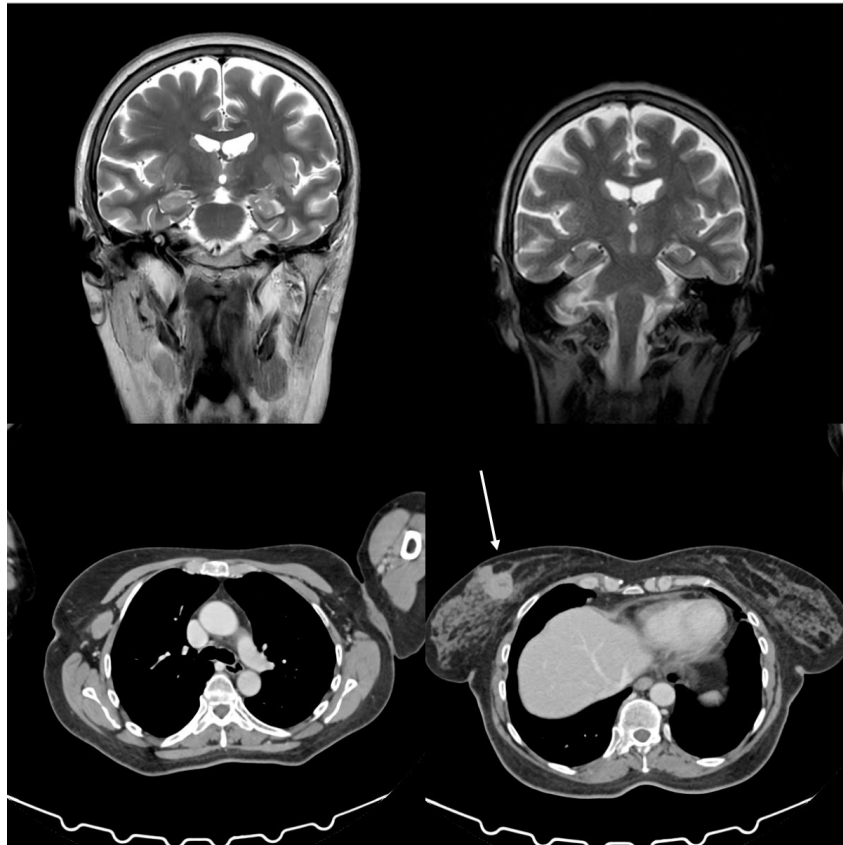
Brain nuclear magnetic resonance showing no metastases, and a CT scan of the thorax and the abdomen showing a mass in the breast cancer (white arrow) and no distant metastases.
